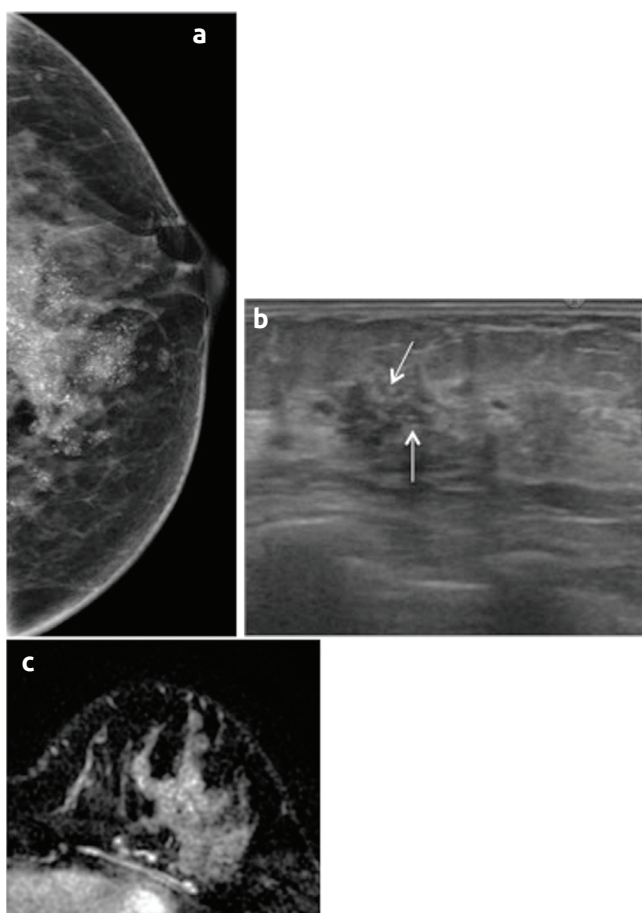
A 45-year-old female patient who presented with a palpable mass. a. Mammography image shows coarse heterogeneous calcifications with regional distribution and asymmetry. b. US image shows hypoechoic areas with microcalcifications (arrows). c. Axial post-contrast subtraction MR image shows NME with heterogeneous internal enhancement in regional distribution. High grade DCIS with RC was diagnosed using US-guided core biopsy. Microinvasion was detected on surgical excision. Both the estrogen and progesterone receptors were positive, HER2 was negative, and the Ki-67 index was more than 20%
